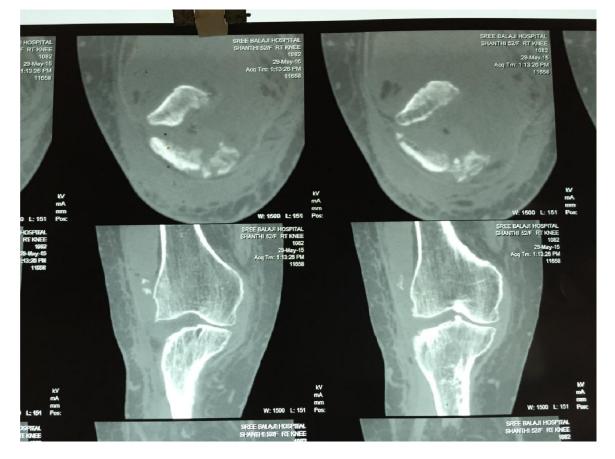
CT scan of the Knee joint showing comminuted transverse fracture of the patella
